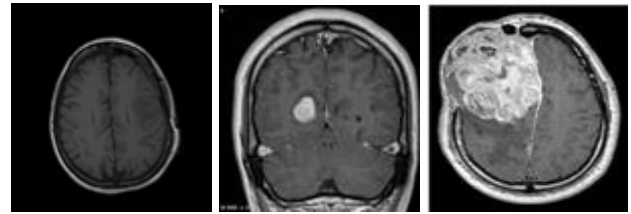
Normal MRI (No Tumor) Fig. 3. Abnormal MRI (Benign Tumor) Fig. 4. Abnormal MRI (Malignant Tumor)
